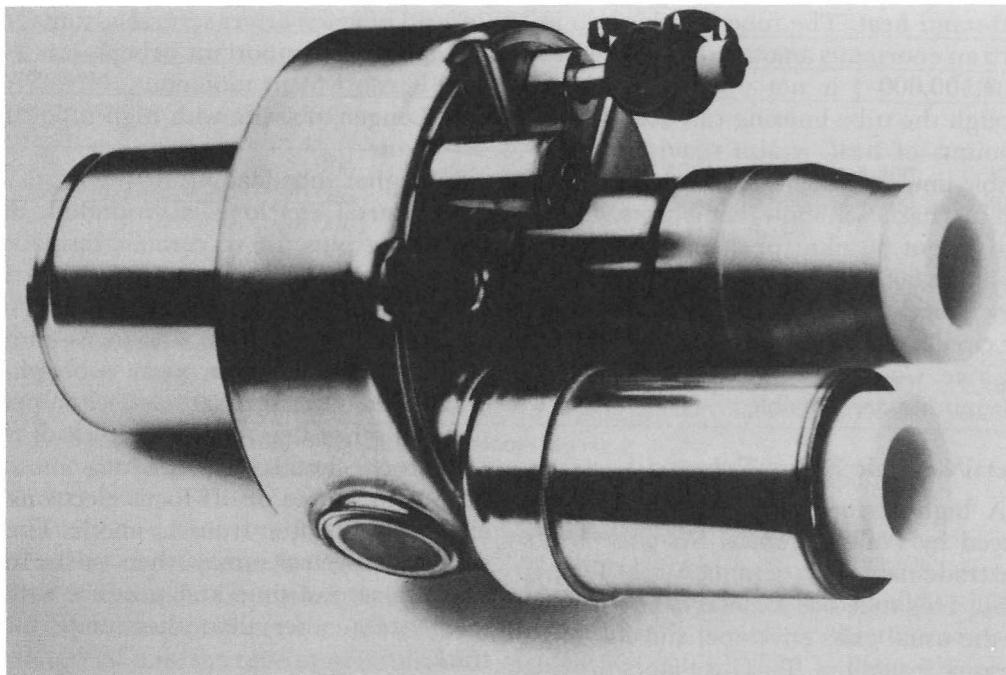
Photograph of a Super Rolatix ceramic x-ray tube. (Courtesy of Philips Medical Systems, Inc., Shelton, CT)
